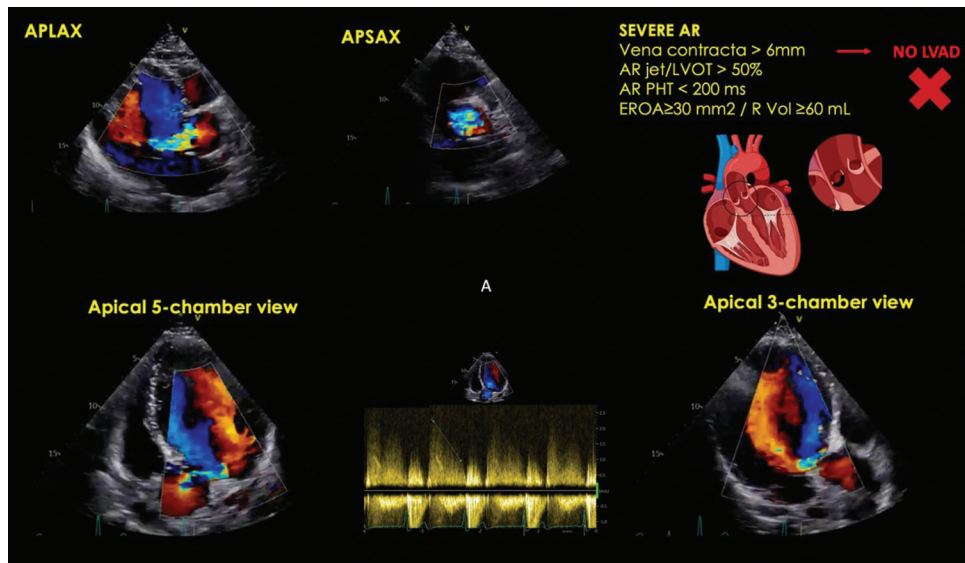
Echocardiographic parameters for the evaluation of aortic regurgitation in left ventricular assist device candidates. Parasternal long-axis view (APLAX) and short axis-view (APSAX) on the top, left and top, center; apical 5-chamber view on the bottom, left; continuous-wave Doppler across aortic valve on the bottom, center; apical 3-chamber view on the bottom, right. AR = Aortic regurgitation, EROA = Effective regurgitant orifice area, LVOT = Left ventricular outflow tract, PHT = Pressure half-time, R Vol = Regurgitant volume
